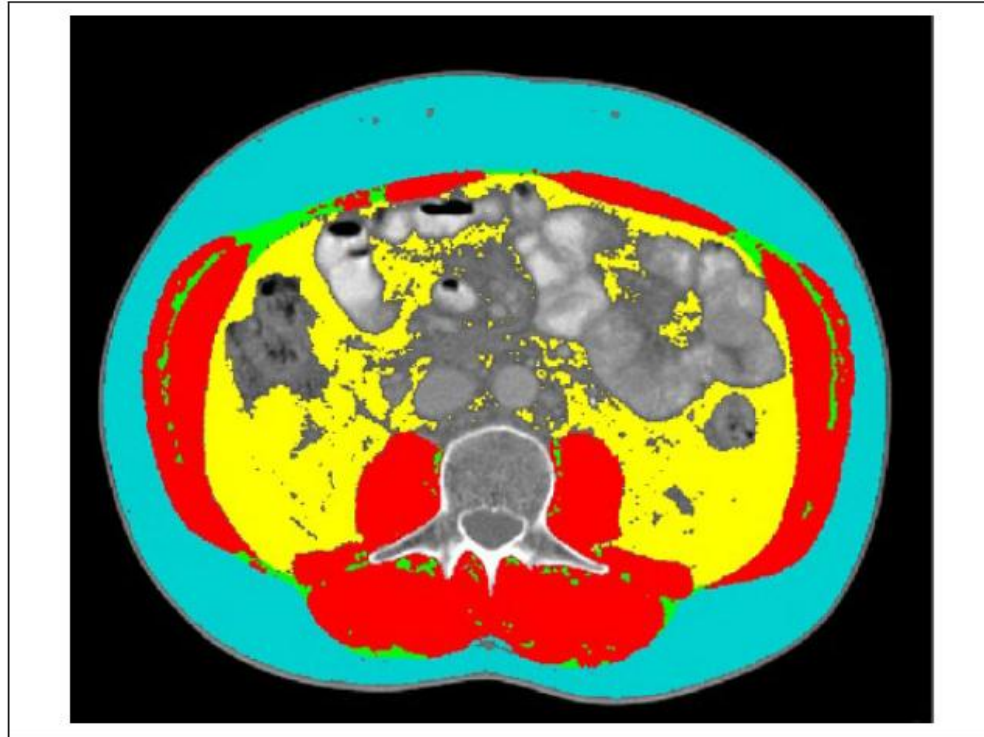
Representative patient showing transverse computed tomography image at the 3rd lumbar vertebrae demonstrating subcutaneous adipose tissue (light blue), abdominal skeletal muscle (red), intermuscular fat (green) and visceral fat (yellow).
